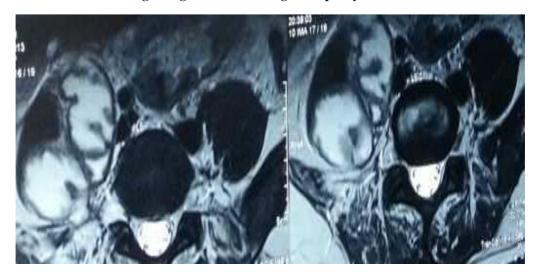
Axial MRI showing L4-5 spondylodiscitis with multiloculated right sided psoas abscess
